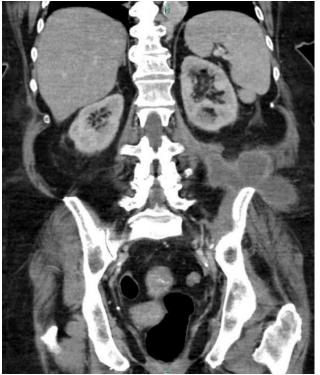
CT abdomen and pelvis with contrast on initial presentation demonstrating "Bear paw sign" unfortunately this was not identified at the time of reporting.
